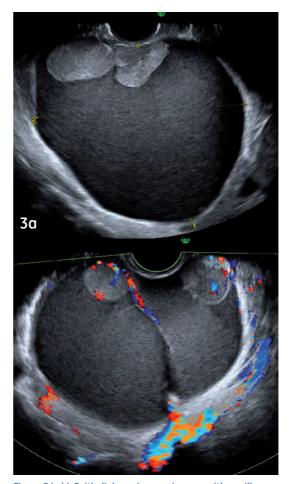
(a,b): Epithelial ovarian carcinomas with papillary projections vascularized at Color Doppler examination
